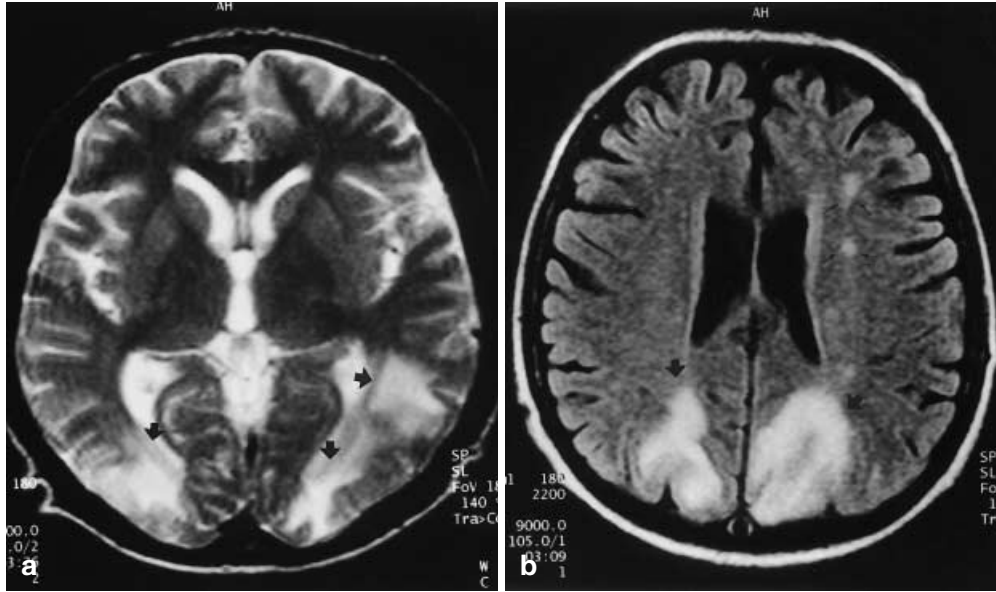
Hypertensive encephalopathy in a 29-year-old man on dialysis therapy who developed headache as well as visual and mental disturbances during dialysis. a Turbo spin-echo T2-weighted axial MRI reveals bilateral occipital and posterior parietal subcortical white matter edema (*arrows*). b fluid attenuated inversion recovery (FLAIR) image of another hypertensive end-stage renal disease (ESRD) patient shows edema (*arrows*) and periventricular white matter changes (*small arrows*)
